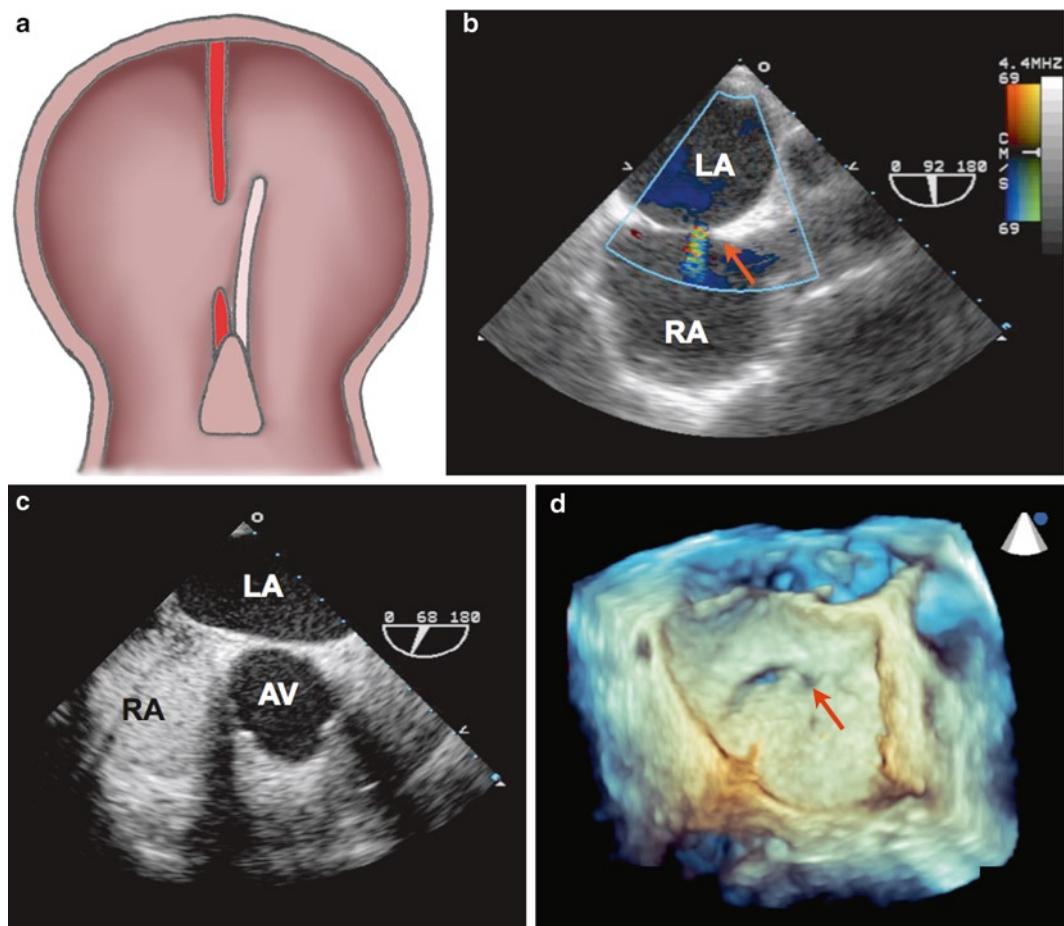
Patent foramen ovale*. Patent foramen ovale (PFO) is the result of lack of fusion of septum primum (left side) and septum secundum (right side) (a) (Photo is courtesy of GM Busato). Color Doppler allows identification of flow across a PFO that commonly creates a small left to right shunt (b). Agitated saline is the contrast medium of choice to confirm and detect the presence of PFO (c). 3D TEE can provide an en-face view of the inter atrial septum. (d) The PFO is seen from the left atrial side.
